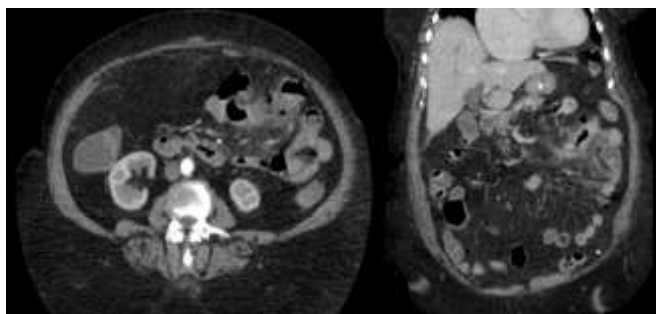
Arterial and portal venous phase CT of jejunal diverticulitis with micro-perforation (Case 1).
